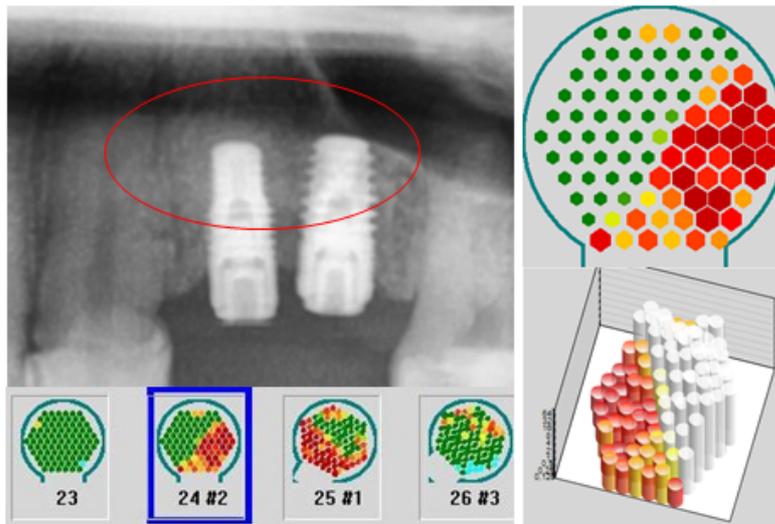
Left window: The 2D-OPG shows implants in area 24 and 25; inconspicuous bone around the implants. Left lower: In contrast to the X-ray the measurement of the bone density adjacent to the implants by CAVITAU displays in red diminished bone density. Right upper: Very clear displays the straight line where the implant (in green) gets in contact with the obvious osteolytic neighbouring jawbone in red. Right lower: White columns display the implant, while directly adjacent jawbone displays diminished bone density.
